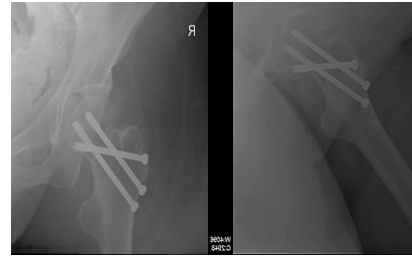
Post-op. plain X-ray, AP view (a) and lateral view (b), showing TLCS fixation
